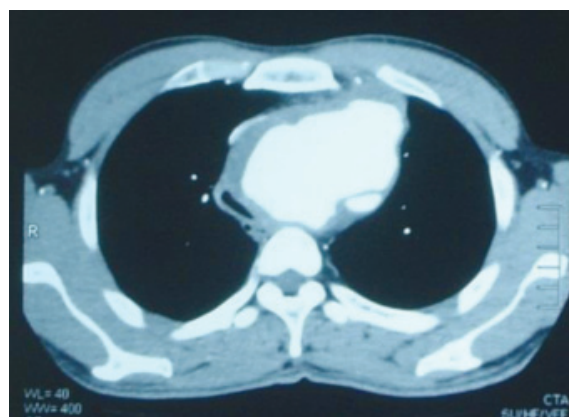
Computed tomography scan showing a large saccular aortic arch aneurysm. The trachea was compressed, narrowed, and displaced to the right.
